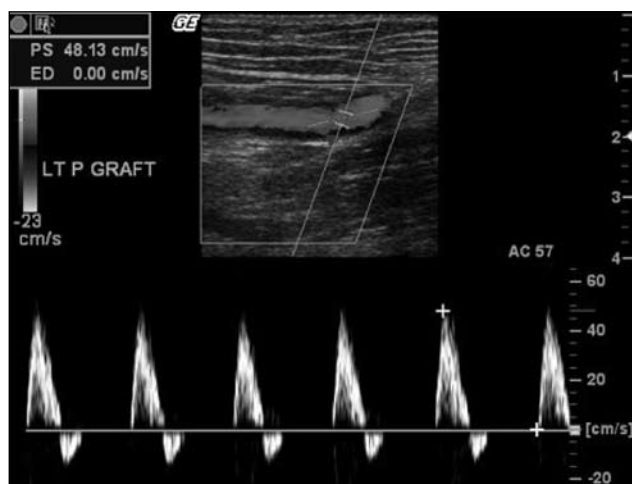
Good blood flow on Colour Doppler of a Saphenous Vein graft and biphasic waves on duplex ultrasound
